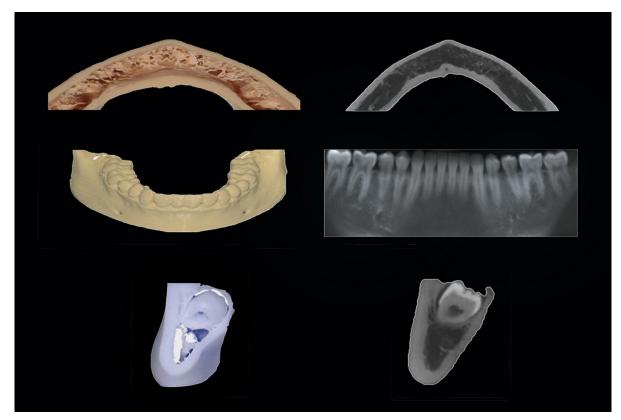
Cone beam computed tomography scanning of cast.
